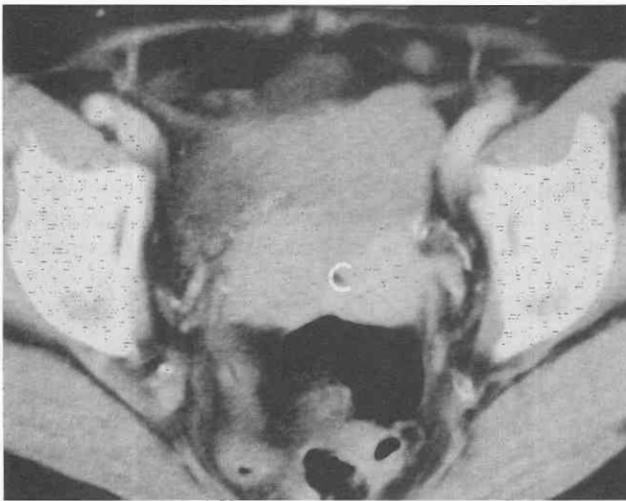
Cervical lymphoma. CT scan shows a homogeneous enhancing mass expanding the cervix (C).
